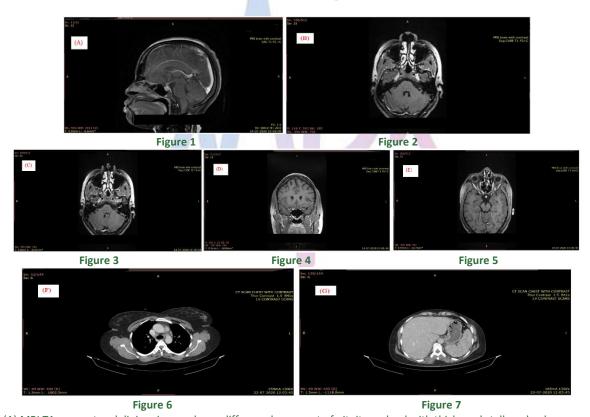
(A) MRI T1 sag post gadolinium image shows diffuse enlargement of pituitary gland with thickened stalk and enhancement; Figure 2: (B) MRI T1 axial post gadolinium-Diffuse thickening and pachymeningeal enhancement surrounding the meckels cave; Figure 3: (C) MRI T1 axial post gadolinium image-Enhancement of bilateral facial nerves at tympanic segments; Figure 4 and 5: (D and E) MRI T1 axial and cor post gadolinium images show enhancement of right optic nerves; Figure 6: (F) Contrast CT chest axial section shows enlarged non necrotic mediastinal nodes; Figure 7: (G) Contrast CT abdomen axial section shows multiple innumerable hypo dense splenic lesions suggestive of granulomas.
